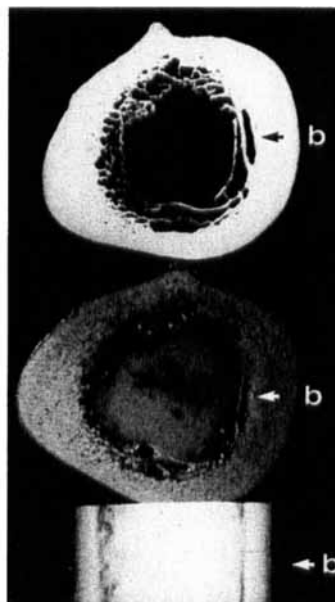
In vitro cementation following bone lavage and drying. No interposition, but specific trabecular arrangement in the femoral wall (b) giving radiolucent line on plain radiograph (b').
